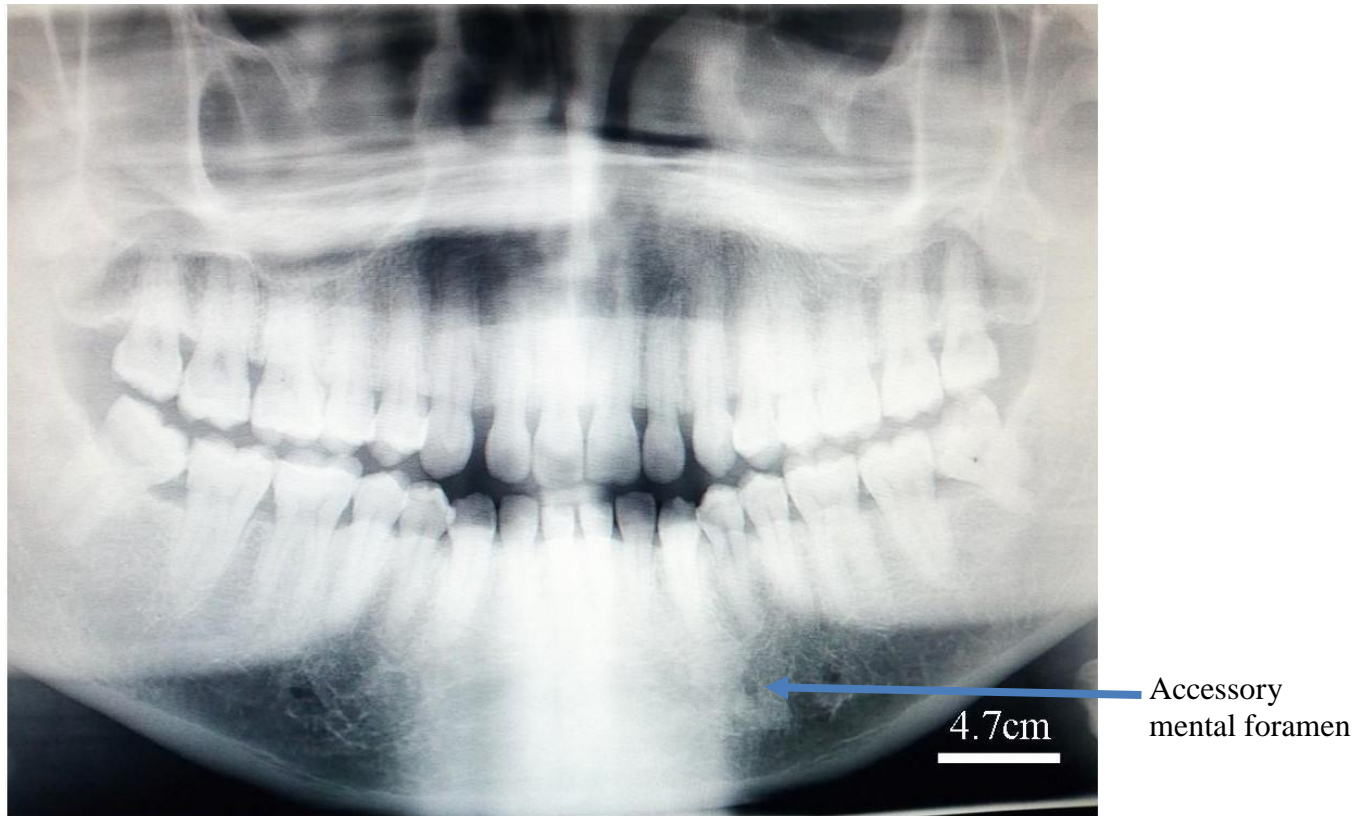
An orthopantomograph with an accessory mental foramen.
